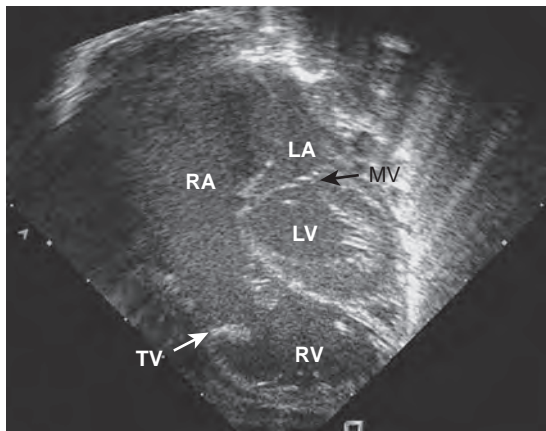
Ebstein anomaly of the tricuspid valve. This echocardiogram shows the apically displaced redundant tricuspid valve tissue and a massively enlarged right atrium with bowing of the atrial septum to the left. LA, Left atrium; LV, left ventricle; MV, mitral valve; RA, right atrium; RV, right ventricle; TV, tricuspid valve. (Reprinted with permission from Baum VC. *Abnormalities of the atrioventricular valves*. In: Lake CL, Booker P, eds. *Pediatric Cardiac Anesthesia*, 4th ed. Philadelphia: Lippincott Williams and Wilkins; 2004.)
